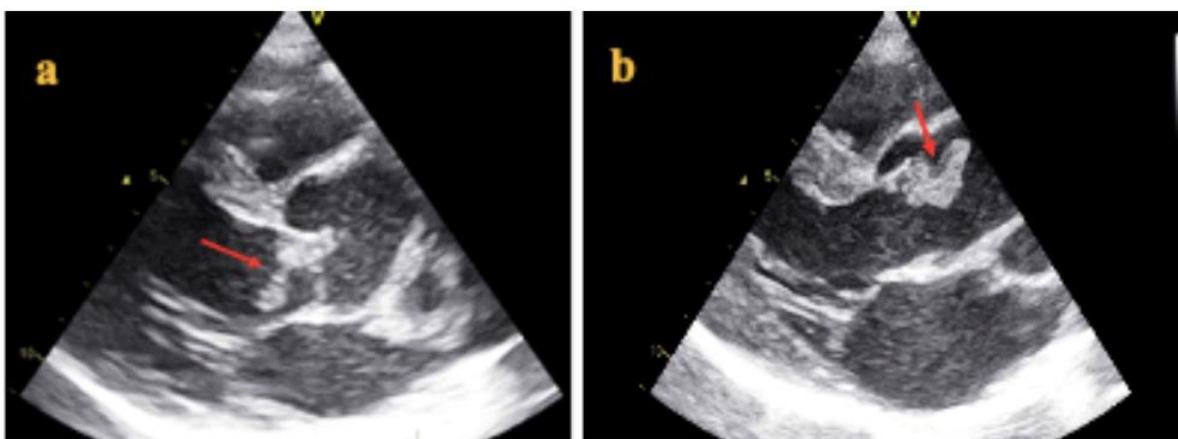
The transthoracic echocardiography in the long-axis parasternal view during diastole (a) and systole (b) reveals a hyper-echoic mass (indicated by the arrows) attached to the ventricular aspect of the nonstenotic right anterosuperior leaflet of the sigmoid valve
